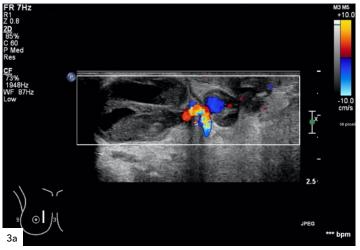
Ultrasound with color flow demonstrates the biopsied complex solid and cystic mass, measuring up to 54 mm, with a prominent arterial vessel feeding a 9-mm, partially thrombosed pseudoaneurysm.
